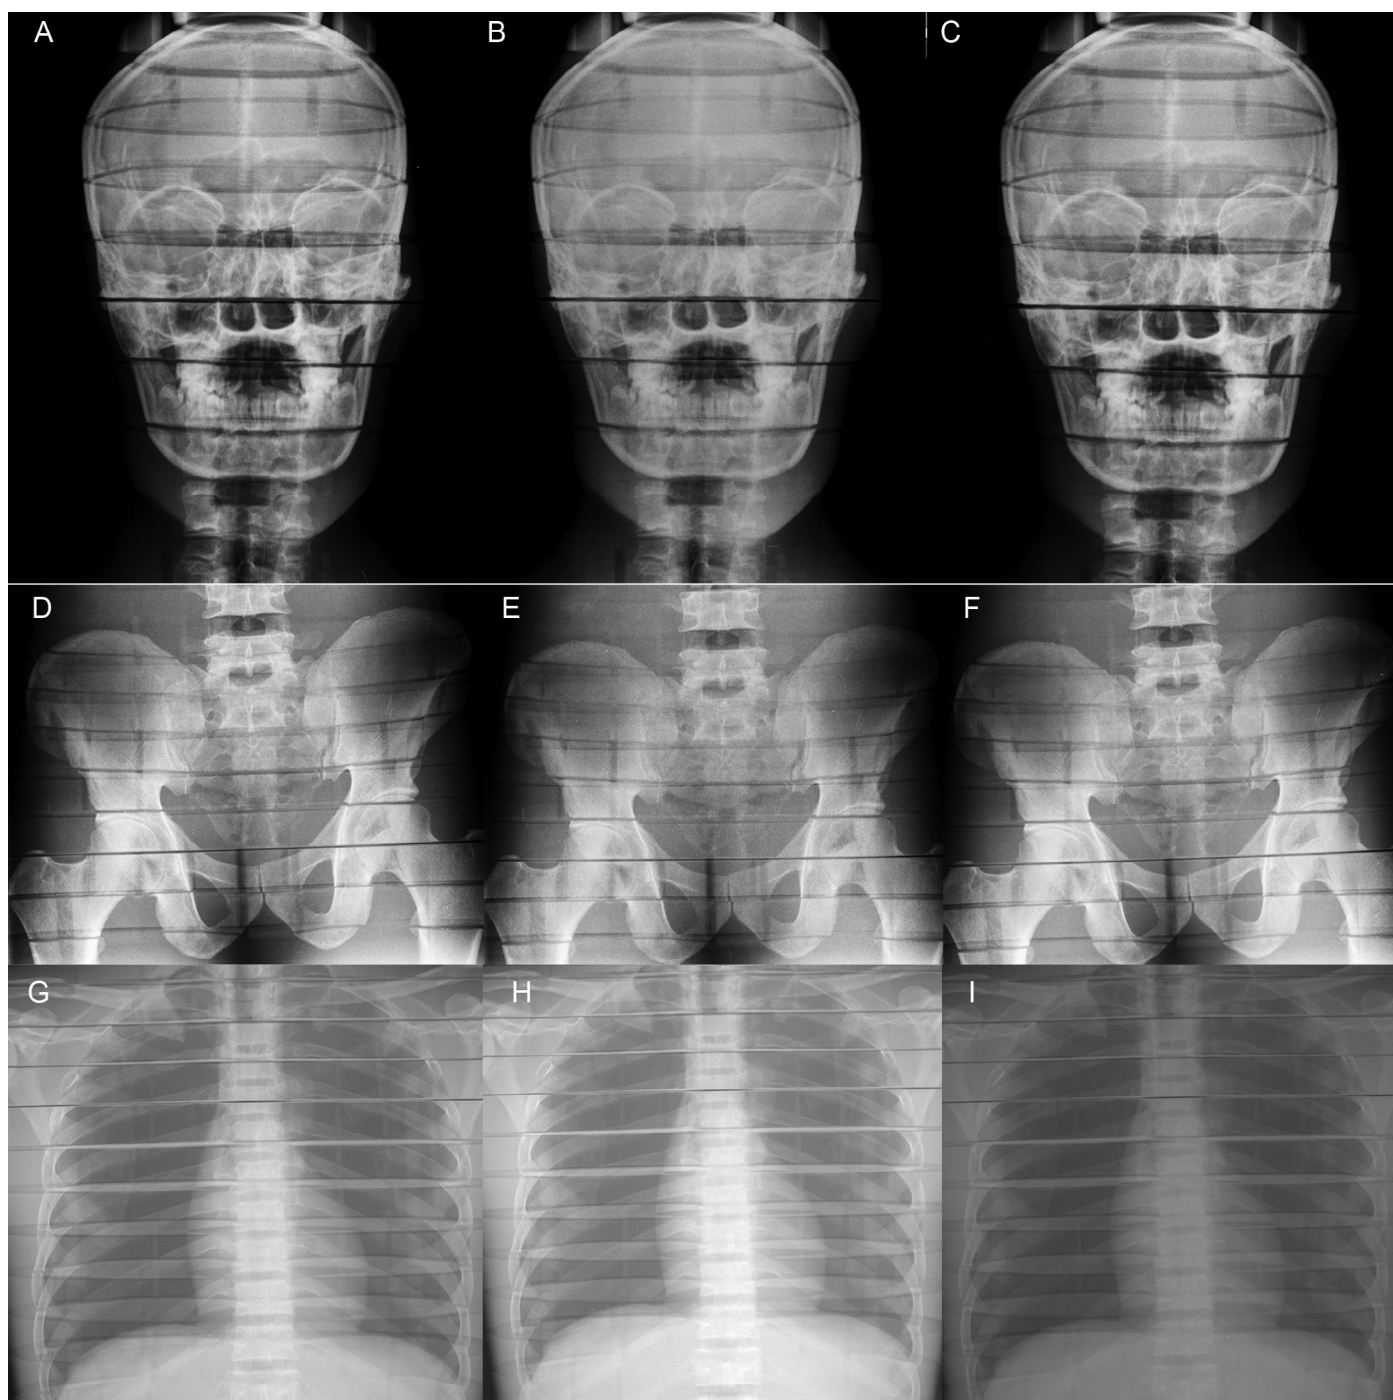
Comparison between radiographic images obtained with higher eDQEs (A, D, and G); with the gold standard technique (B, E, and H); and with the routine techniques of our institution are shown in (C, F, and I). All images were evaluated with scores of +2 by radiologists for skull, pelvis and chest.
